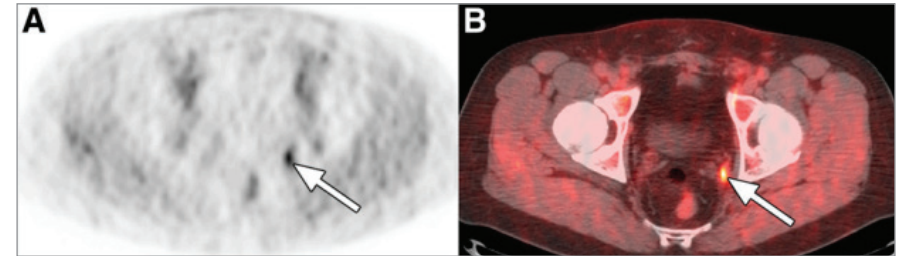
Prostate cancer imaging with [¹⁸F]Fluciclovine. [¹⁸F]Fluciclovine PET (A) and [¹⁸F]Fluciclovine PET/CT (B) images from a patient with suspected recurrence of prostate cancer demonstrate focal uptake in left pelvic lymph node metastasis that measures less than 1 cm in short-axis diameter (indicated with arrows). Biopsy demonstrated recurrent prostate cancer in this location.[2]
